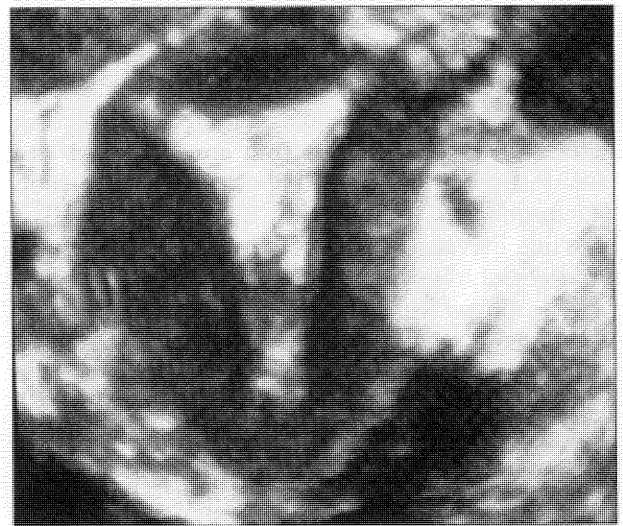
3D sonogram of the patient in Figure 1. Note the normal contour of the uterus above the obstruction.
